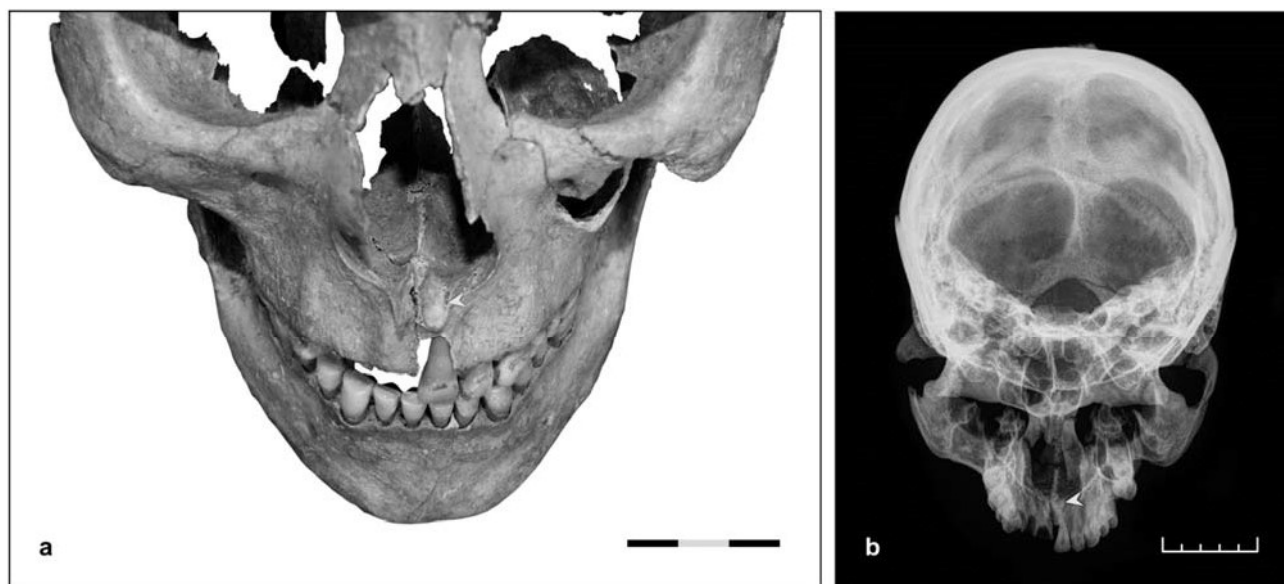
Supernumerary tooth - mesiodens - located between the incisors of the maxilla of a 30–40-year-old male, extending into the nasal cavity and causing asymmetry of the *apertura piriformis* (a). The X-ray shows its pin-like shape (b). (Grave No 4811; photo by Zdeněk Tvrdý; X-ray by Jan Holub).
